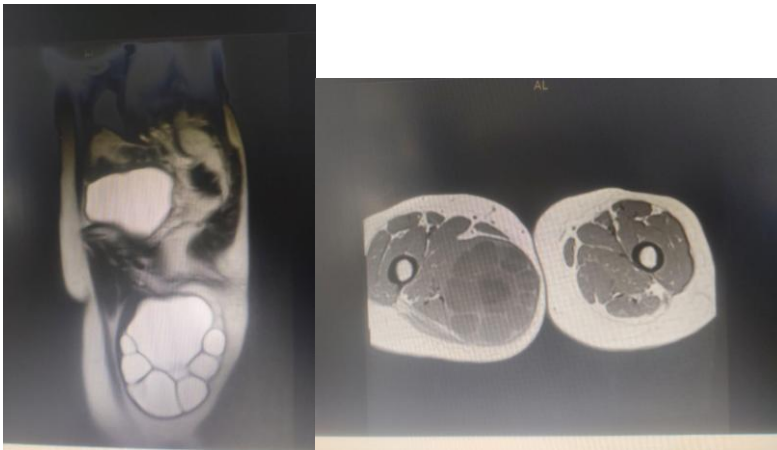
and 5 MRI pelvis showing right gluteal hydatid cyst with intramuscular extension.
